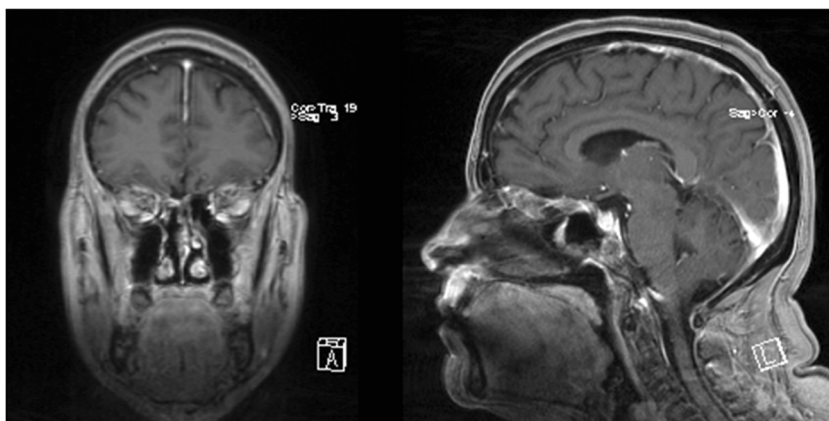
Six month post-operative MRI showing no recurrence of OGM
